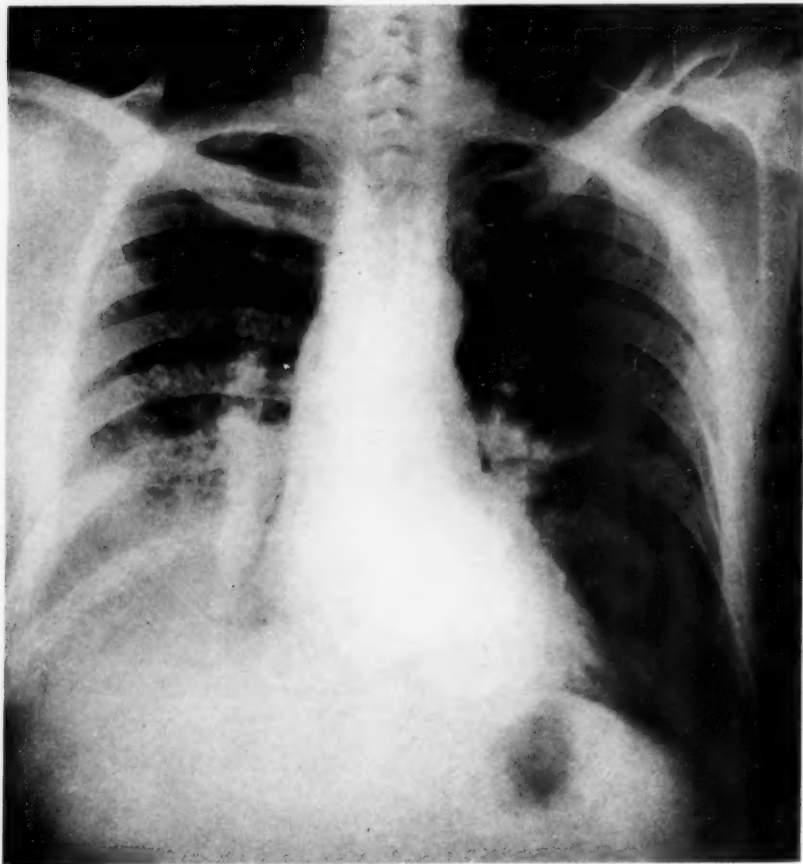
Roentgenograph of chest of S. B., March 1934, during the fourth attack of acute respiratory infection, five years after the first attack.
